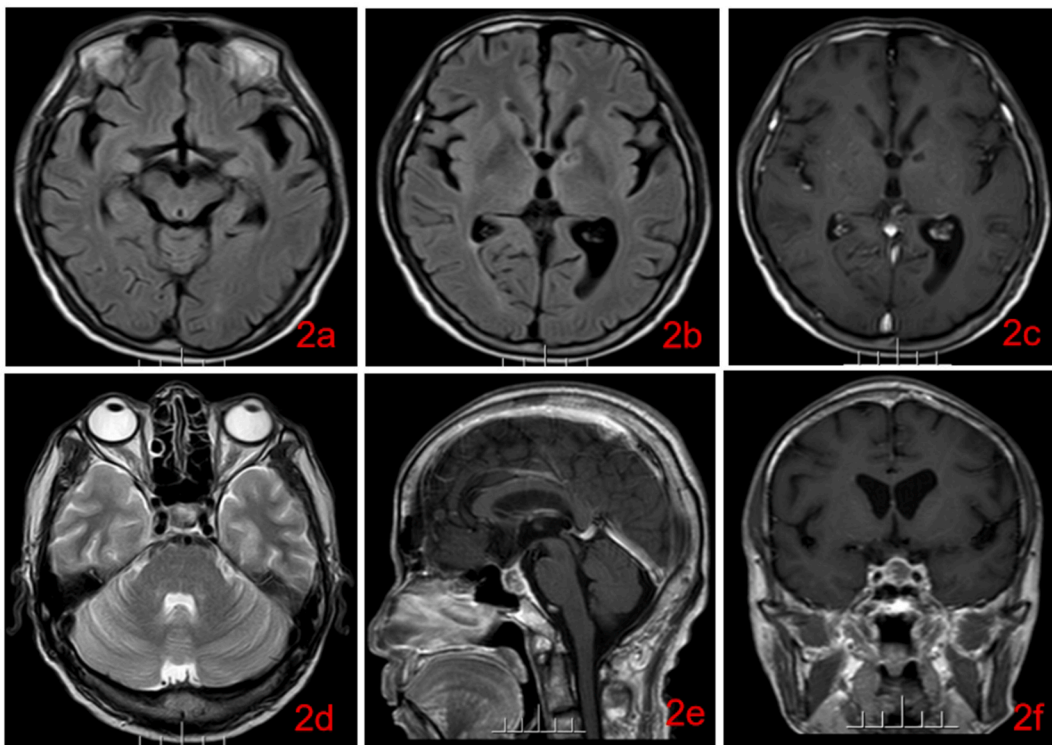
MRI 10 days following treatment initiation, axial T2/FLAIR showing hyperintensity of the optic tract, a low signal intensity inner and a high signal intensity outer of the left basal ganglia (2a, 2b). Enhanced axial T1W demonstrating multi-punctate and linear enhancements in the left basal ganglia and leptomeninges (2c). Axial T2W showing a circular asymmetry density in the sella turcica and suprasellar region (2d). Enhanced sagittal T1W and enhanced coronal T1W demonstrating a ring-like enhancement in the sella turcica and suprasellar region (2e, 2f). The imaging changes (2a–2f) indicate a significant reduction in the observed inflammatory changes as compared to the baseline study.
